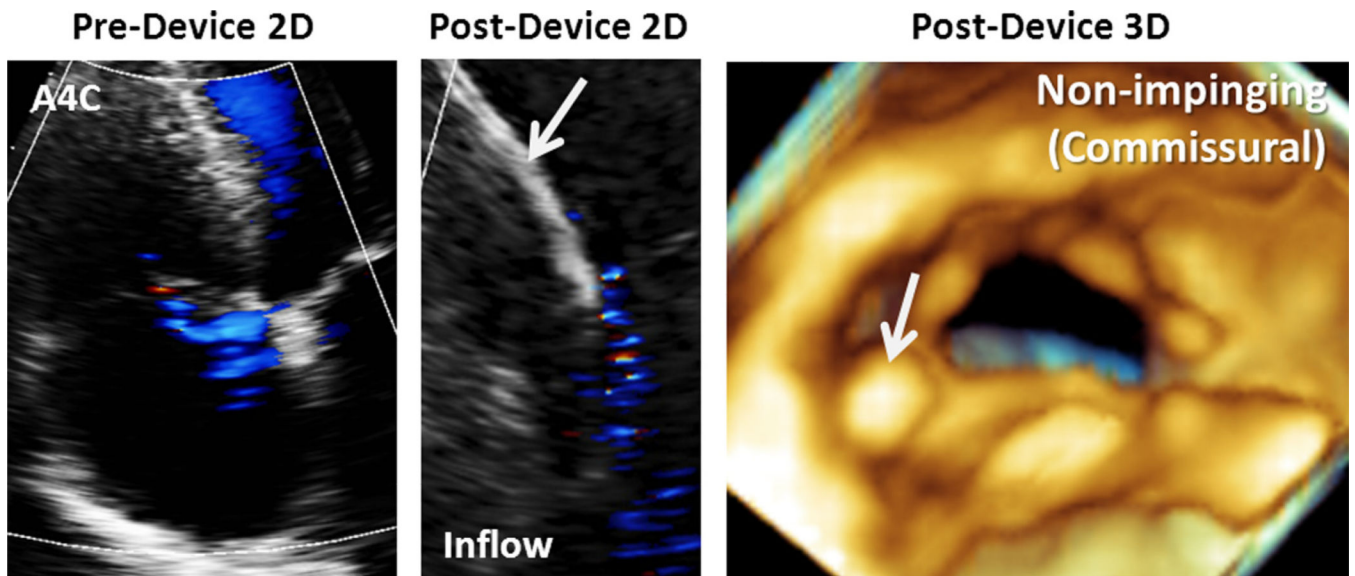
Noninterfering lead. Color flow recordings of the TV showing trace TR before device lead placement (*left*) and trace TR after device lead implantation (*middle*). Three-dimensional zoom (*right*) confirms device lead in the posteroseptal position. *White arrow* points to device lead. *A4C*, Apical four-chamber; *inflow*, RV inflow view. See also Video 3.
